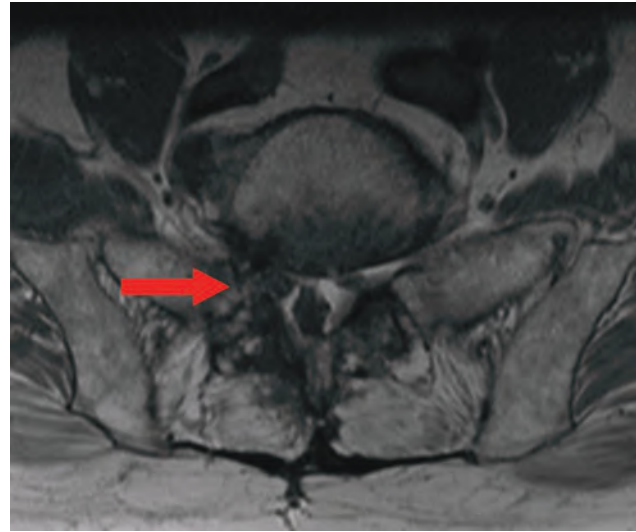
MRI revealing extensive scar tissue in the right L5–S1 lateral recess and neural foramen (axial view). Red arrow points to the L5–S1 neural foramen.
